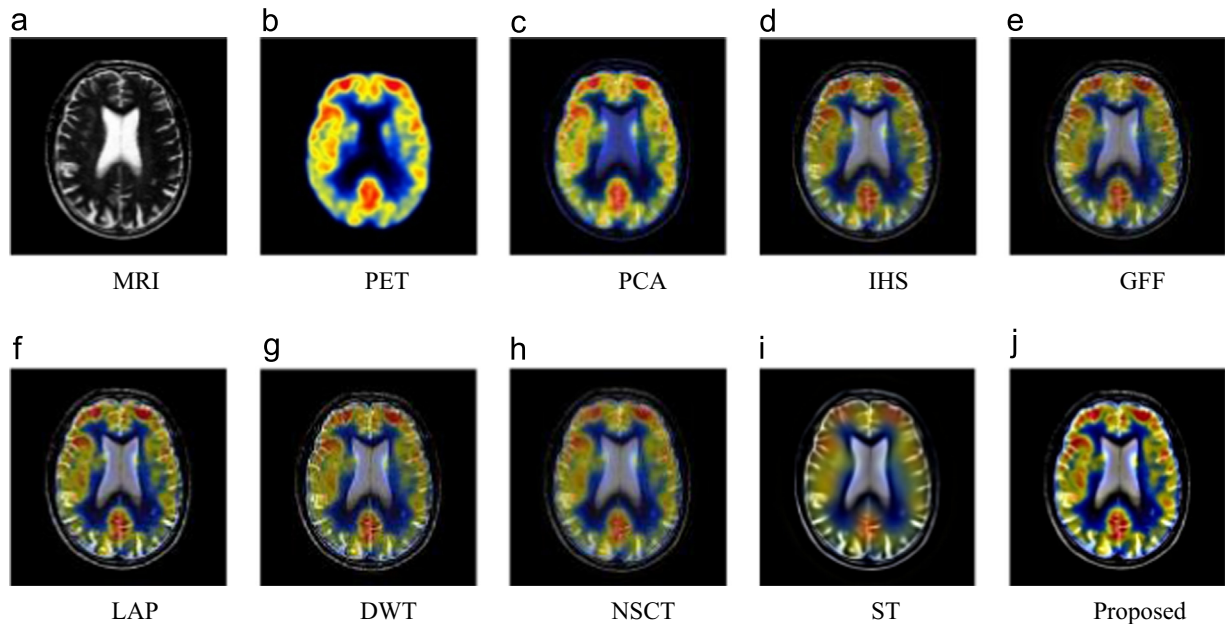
Example 2: Performance comparison of different methods on MRI-PET fusion.
